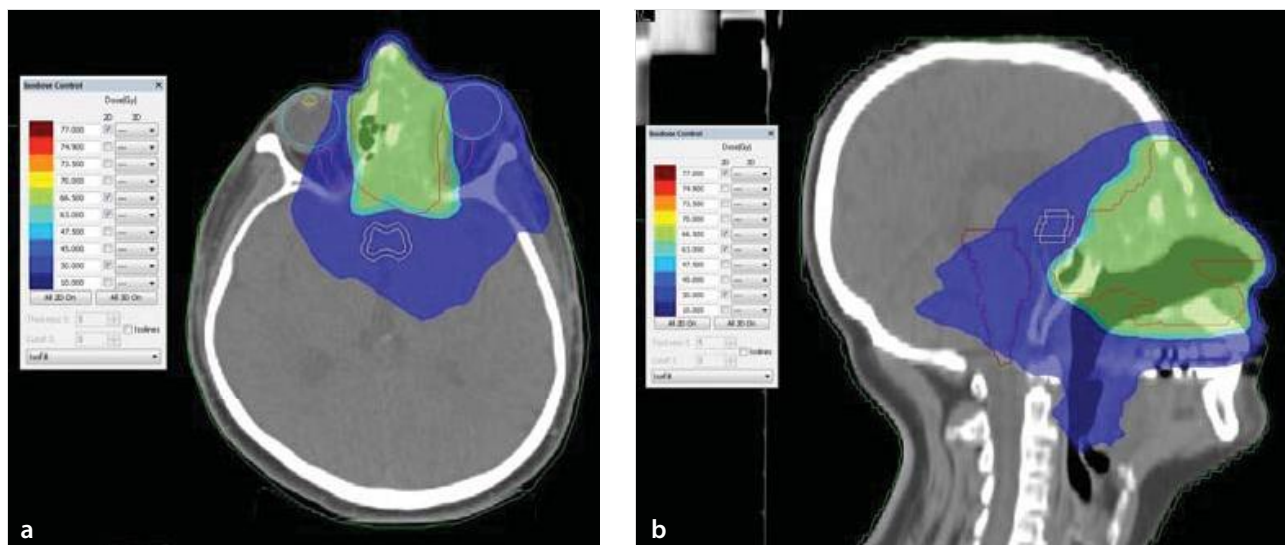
Planning CT images showing radiation dose distribution, in axial (a) and sagittal (b) views. The dose is displayed in isodose bands; green: 66.5 Gy (95% of prescribed dose of 70 Gy), turquoise: 63 Gy (90% of prescribed dose of 70 Gy), blue: 30 Gy.
